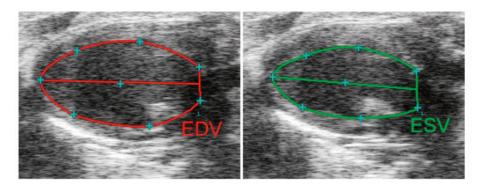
End-diastolic volume (EDV) and end-systolic volume (ESV) in parasternal long-axis view.
